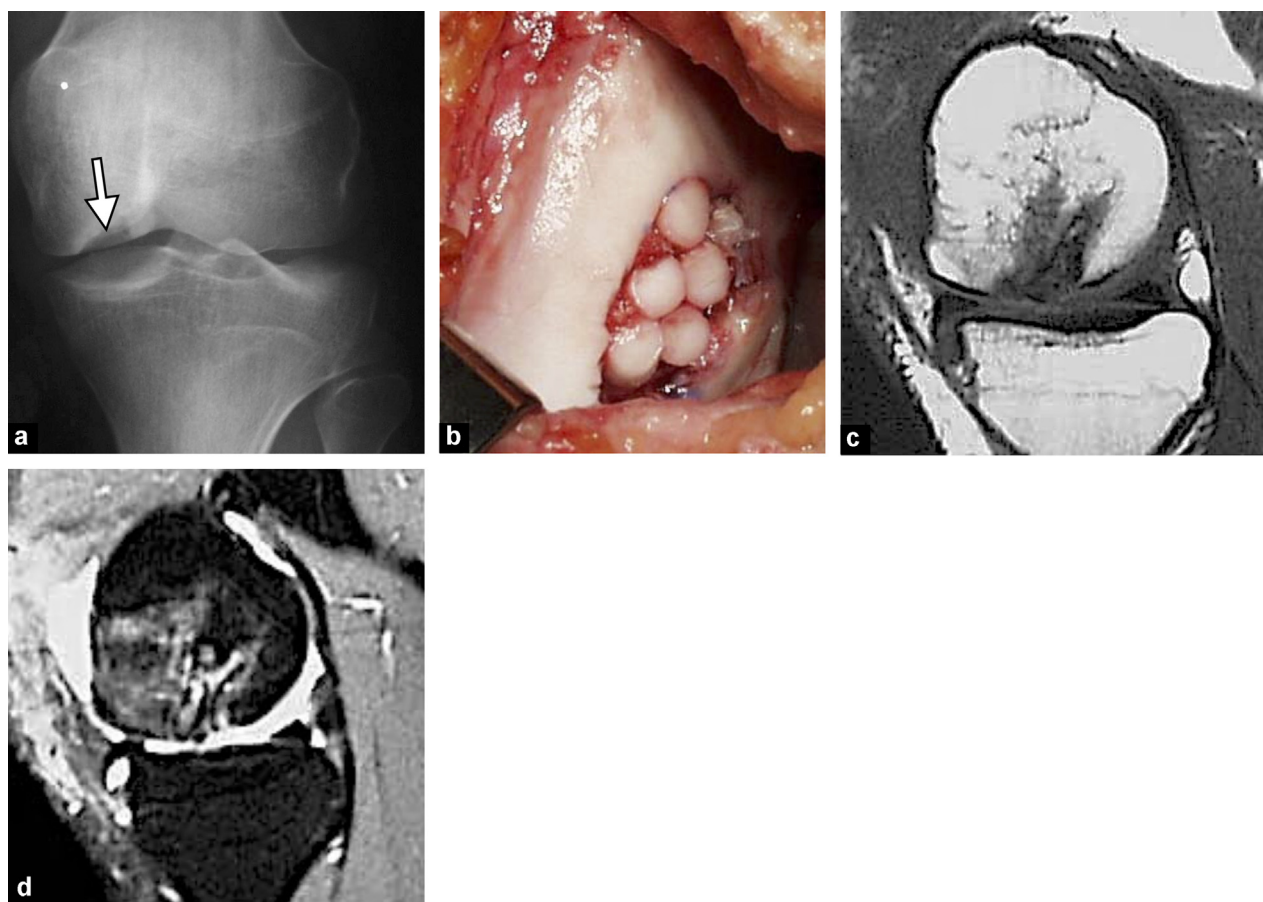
Osteochondral graft "mosaicplasty" type: a: osteochondritis on initial radiograph (arrow); b: intraoperative view of osteochondral plugs; c: T1-weighted MR image in the sagittal plane; d: fat-suppressed PD-weighted sequences in the sagittal plane 6 months after surgery. Persistent edema-like signal in the plugs and adjacent bone marrow.
